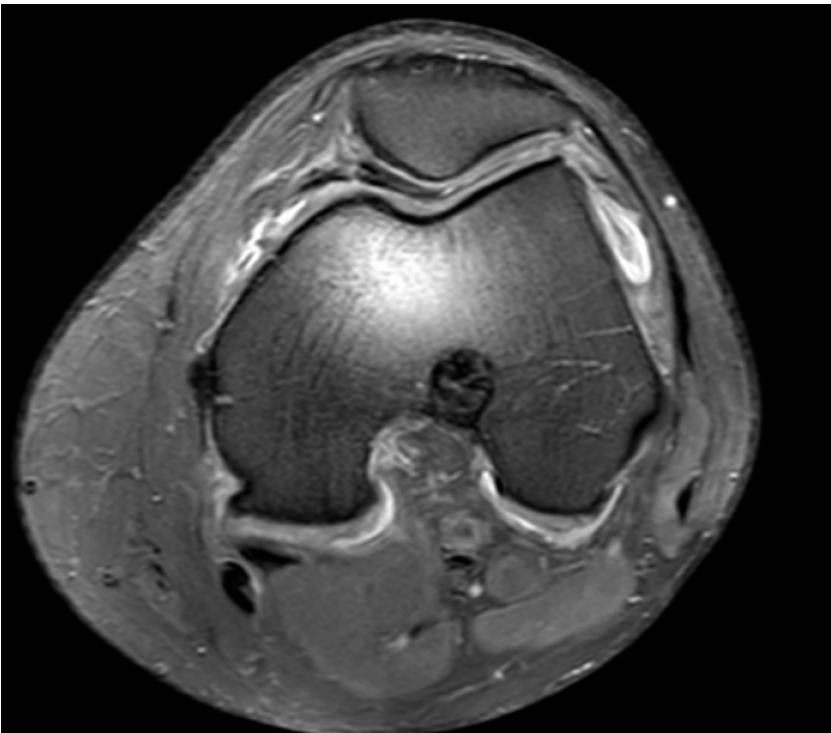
Axial PDW MRI showing diffuse synovitis in a 27-year-old patient following post ACL reconstruction.
